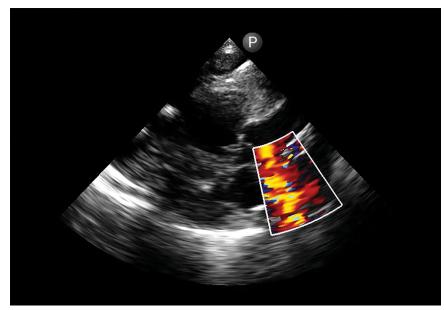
Transthoracic echocardiography demonstrated right-to-left shunt flow from the right pulmonary artery to the left atrium.
